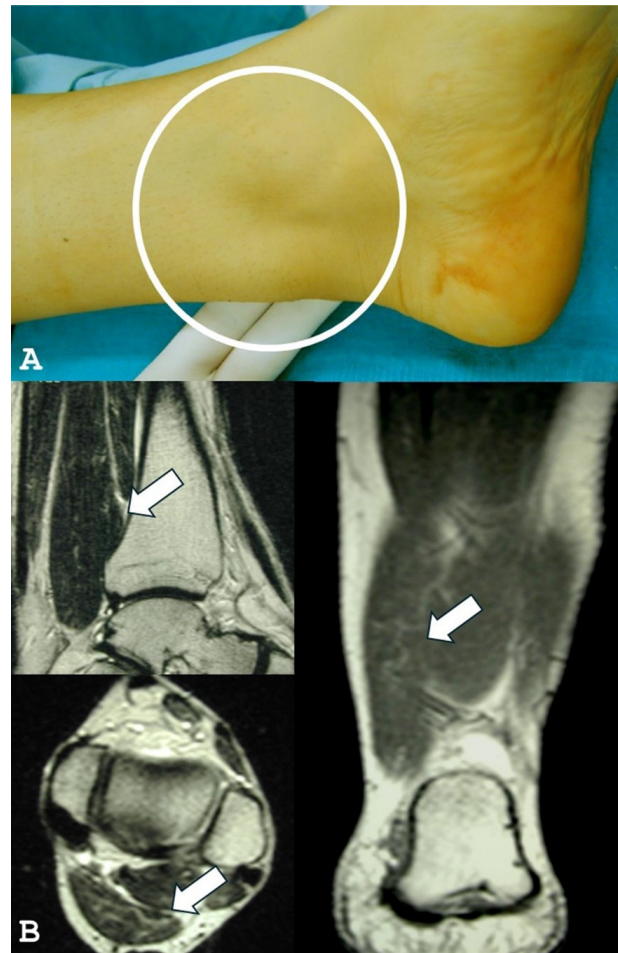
Case 2 with left ASM and chronic posterior ankle pain. (A) Palpable and visible mass in the postero-medial aspect of the ankle (white circle). (B) T1 weighted MRI scans with visualization of ASM (white arrows) in sagittal, axial and coronal planes.
